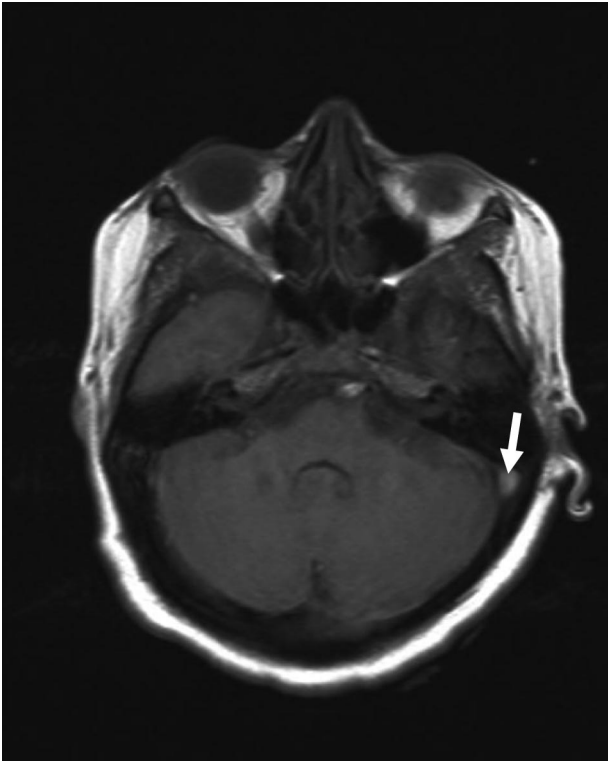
Flair magnetic resonance image showing hypersensitivity signal at left sigmoid sinus (arrow).
